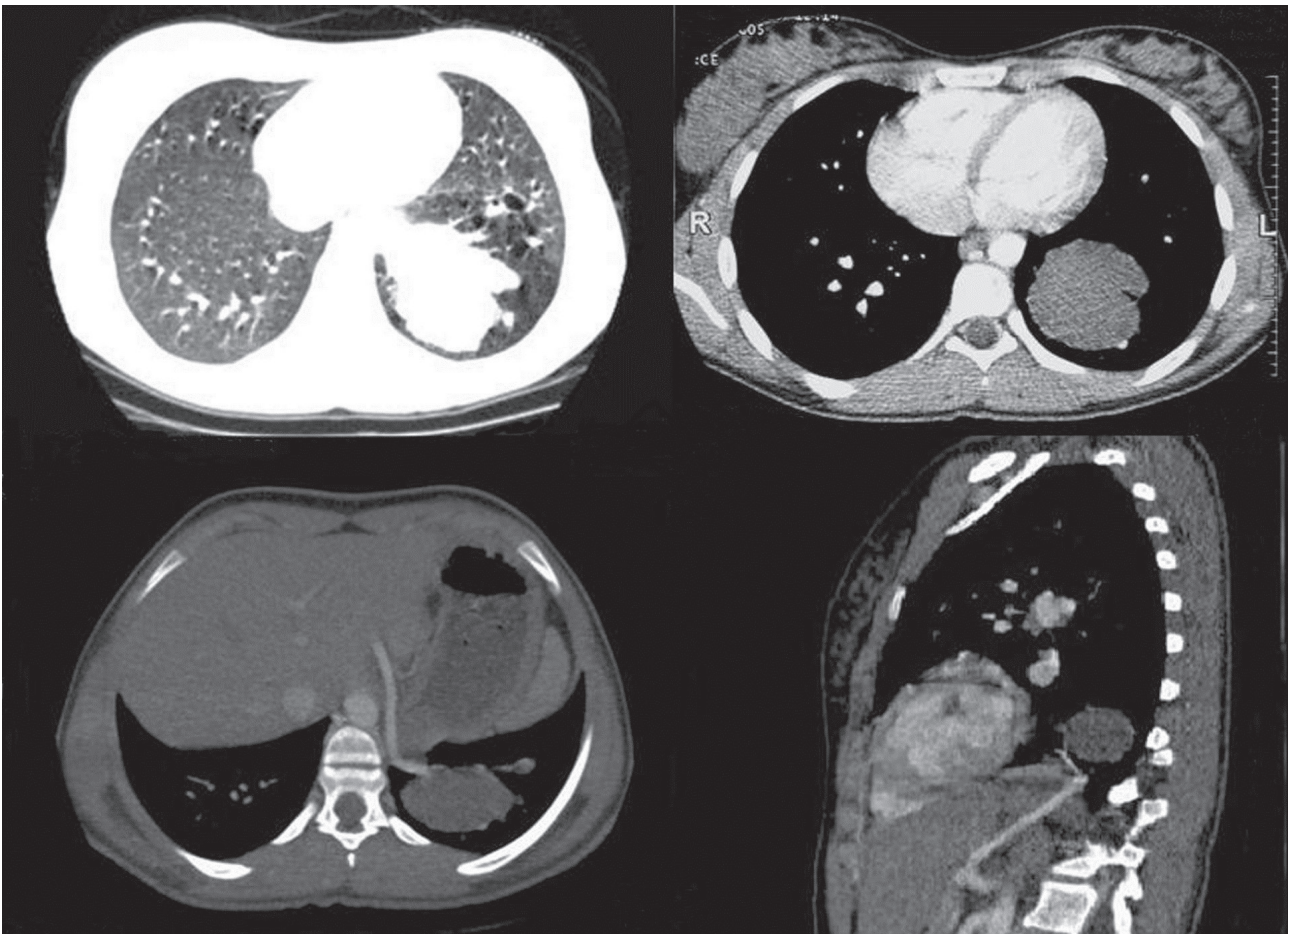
CT Angiogram image showing a solid mass in the left lower lobe supplied by an aberrant systemic artery arising from the celiac trunk
